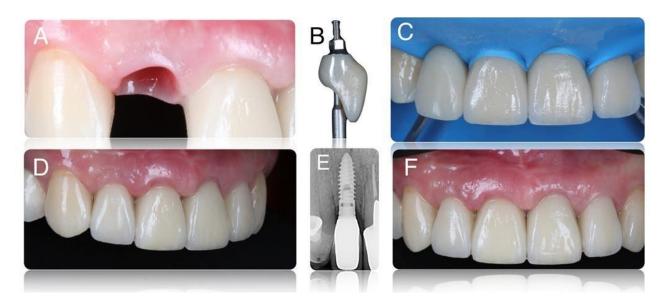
A - view of the mucous before fixing the permanent crown on the implant; B - crown profile; C - fixation of restorations; D, E, F - one week after fixation . X-ray control.
